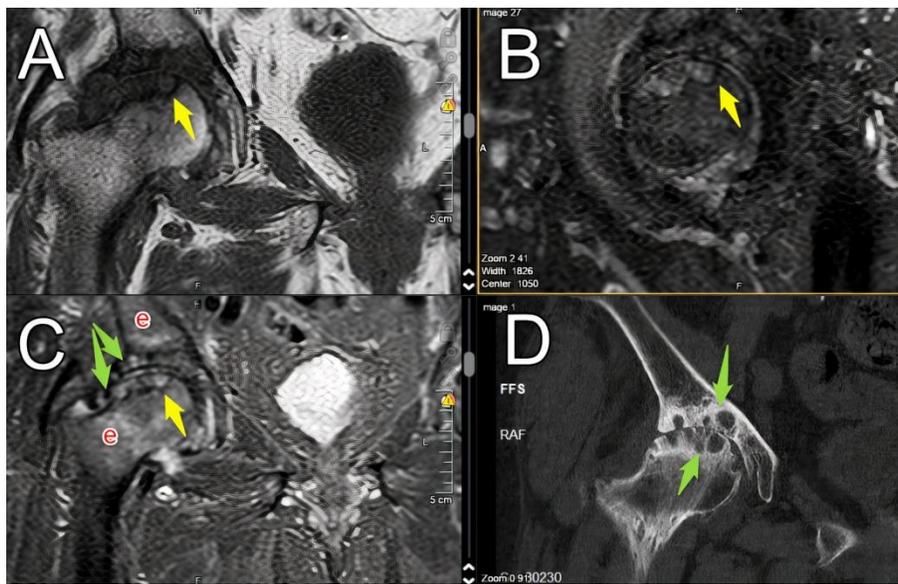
selected images from coronal MRI T1 (A), sagittal PDW-SPAIR (B), coronal MRI STIR (C), and complementary coronal CT (D) in a case of advanced osteoarthritis secondary to AVN. serpentine geographic low signal line surrounding an area of abnormal signal (yellow arrows). Osteoarthritic changes with narrowed irregular joint spaces and marginal osteophytes. Note the subchondral pseudocysts (green arrows) and the edema signal both displayed as low signal in T1 turning high in STIR. The osteoarthritic changes are also nicely demonstrated by the complementary CT
